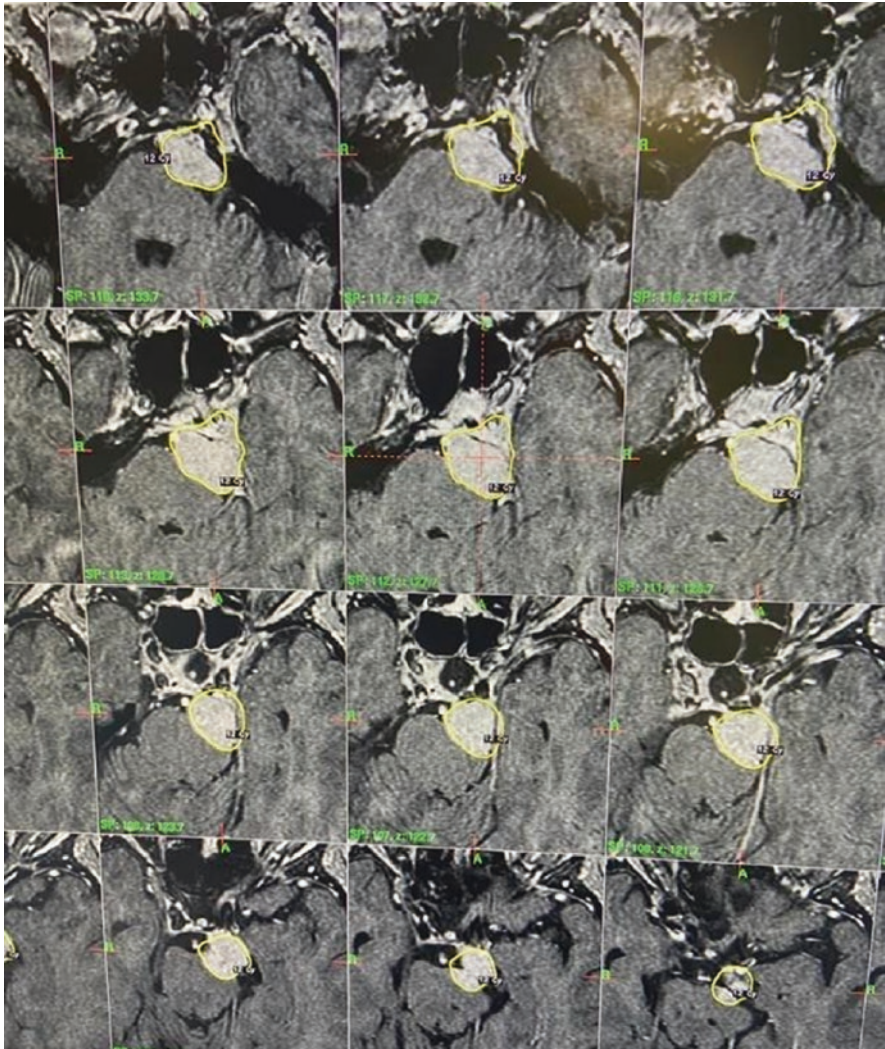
This is a 68-year-old woman found incidentally to have a 2 cm meningeoma in the left retroclival/cavernous sinus region, indenting the left anterior brainstem. She was treated with Gamma Knife (postcontrast T1 weighted axial MRI images from the time of Gamma Knife treatment)
